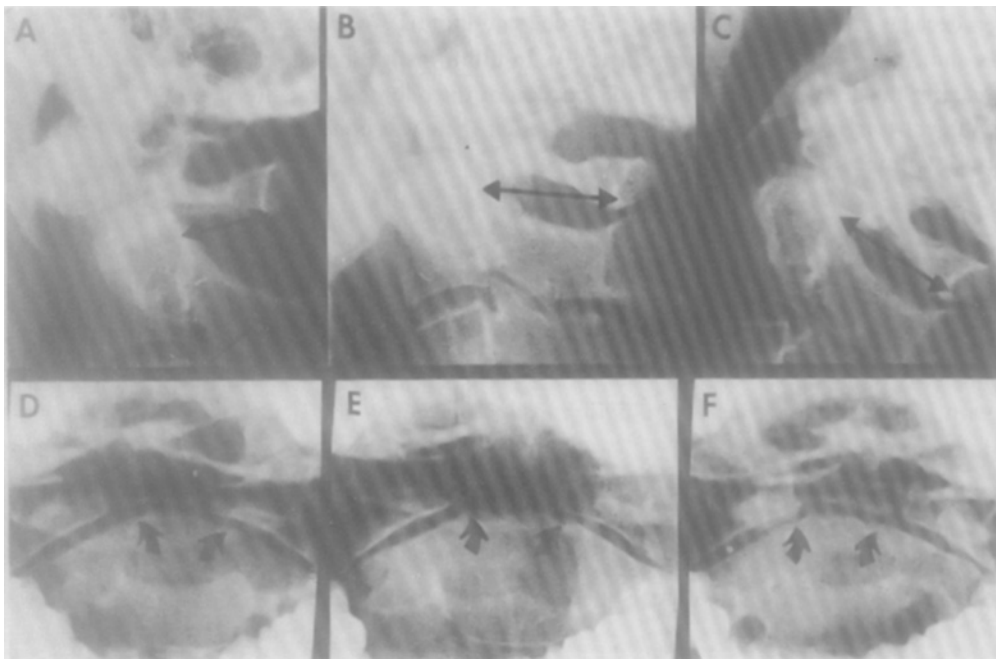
Radiography from a 54-year-old man who 8 years earlier sustained an odontoid fracture. A: Lateral view showing the reduced fracture. B: Lateral view showing a healed posterior fusion.*
